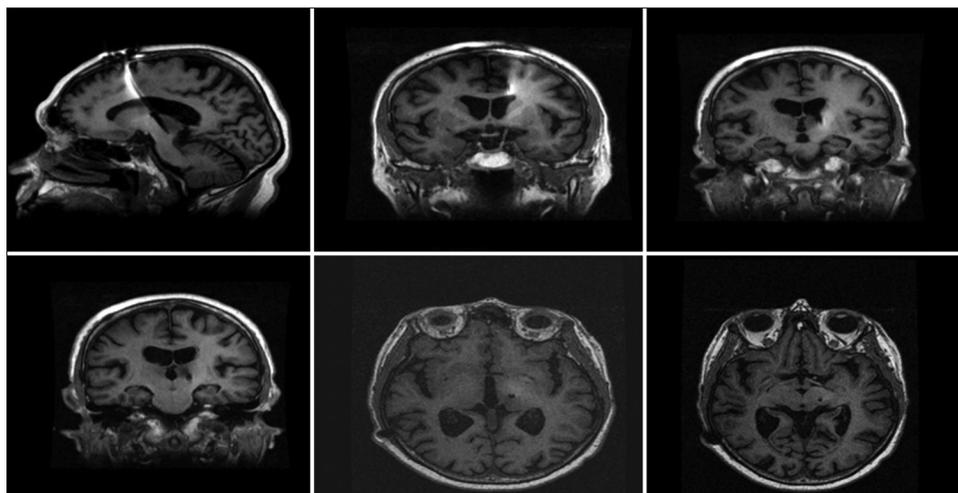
Ventral intermediate (VIM) trajectory. T1 magnetic resonance imaging showing trajectory of the left VIM electrode. Top left – sagittal view of electrode at target, top middle – coronal view of electrode entering left lateral ventricle, top right – coronal view of electrode exiting left lateral ventricle, bottom left – axial view of electrode at target.
